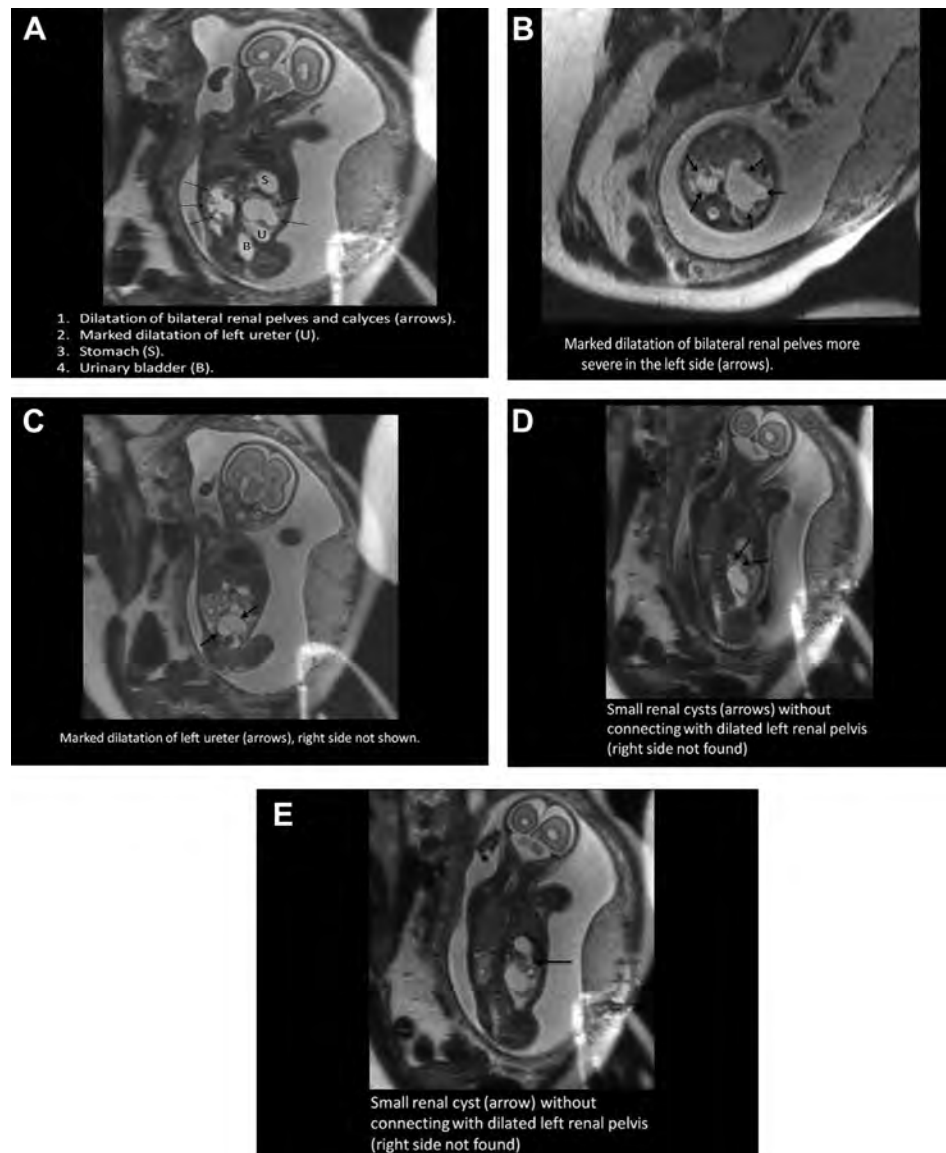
Prenatal magnetic resonance imaging at 21 weeks' gestation showed: (A) dilation of bilateral renal pelves and calyces (arrows), and marked dilation of left ureter (B = urinary bladder; S = stomach; U = ureter); (B) marked dilation of bilateral renal pelves (arrows) with more severe condition on the left side; and (C–E) small renal cysts (arrows) in the left kidney without connection with the dilated renal pelvis.
